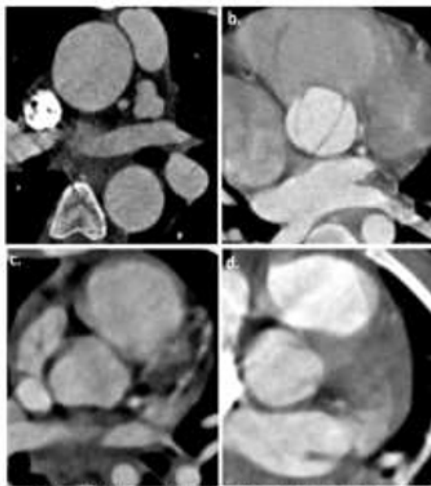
Representative axial cardiac FLASH CT images through the left LCA. Subpanels show the four image quality scores: 1 - Excellent, no artifacts (a); 2 - Good, mild artifact (b); 3 - Acceptable, moderate artifact present but images still interpretable (c); 4 - Unevaluable, severe artifact renders interpretation not possible (d).
